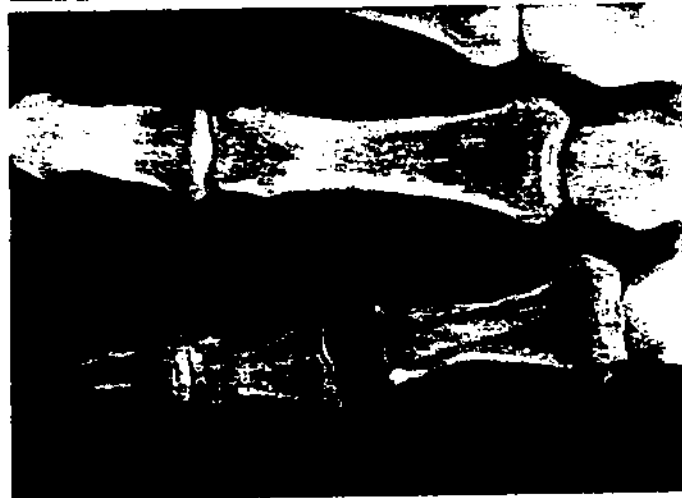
Long-standing dislocation of proximal interphalangeal joint of little finger in young athletic man. B: Roentgenogram showing excellent position and tolerance of implant 3 years after surgery. C and D: Patient recovered full use of hand with excellent flexion and extension.
